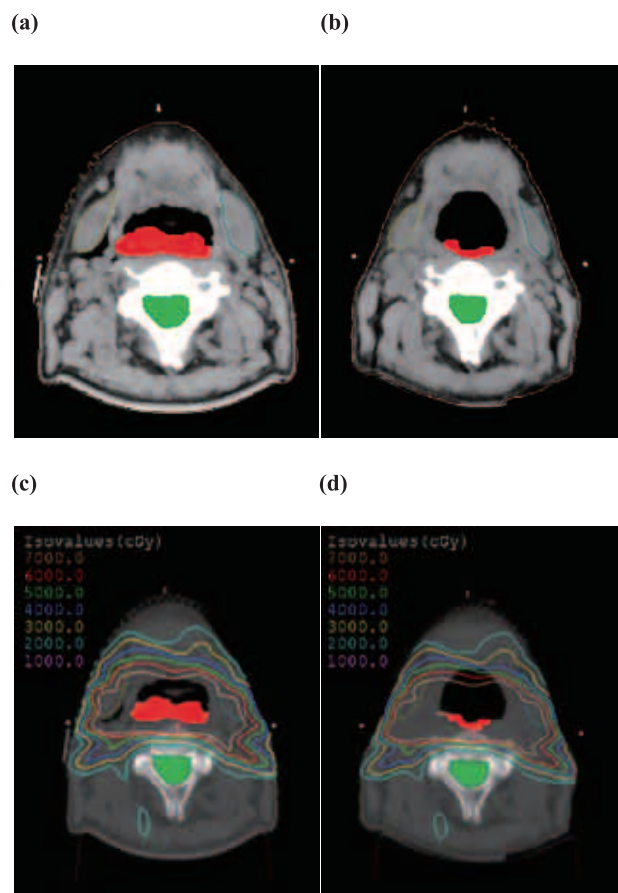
Axial images of computed tomography (CT) of a patient with oropharyngeal cancer, Gross tumor volume and spinal cord were delineated on CT.
